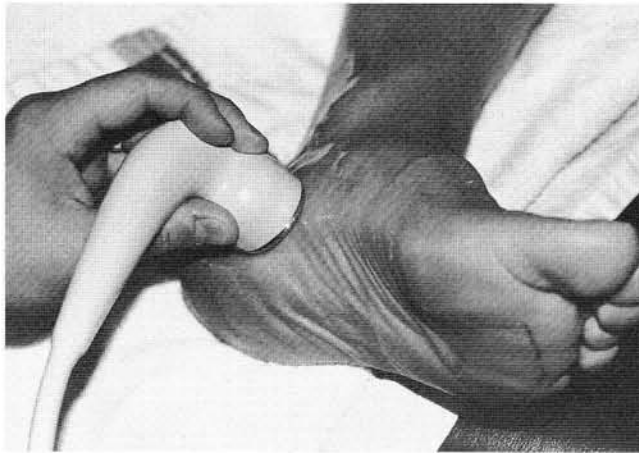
The use of ultrasound to the heel provides deep heat and symptomatic relief.
